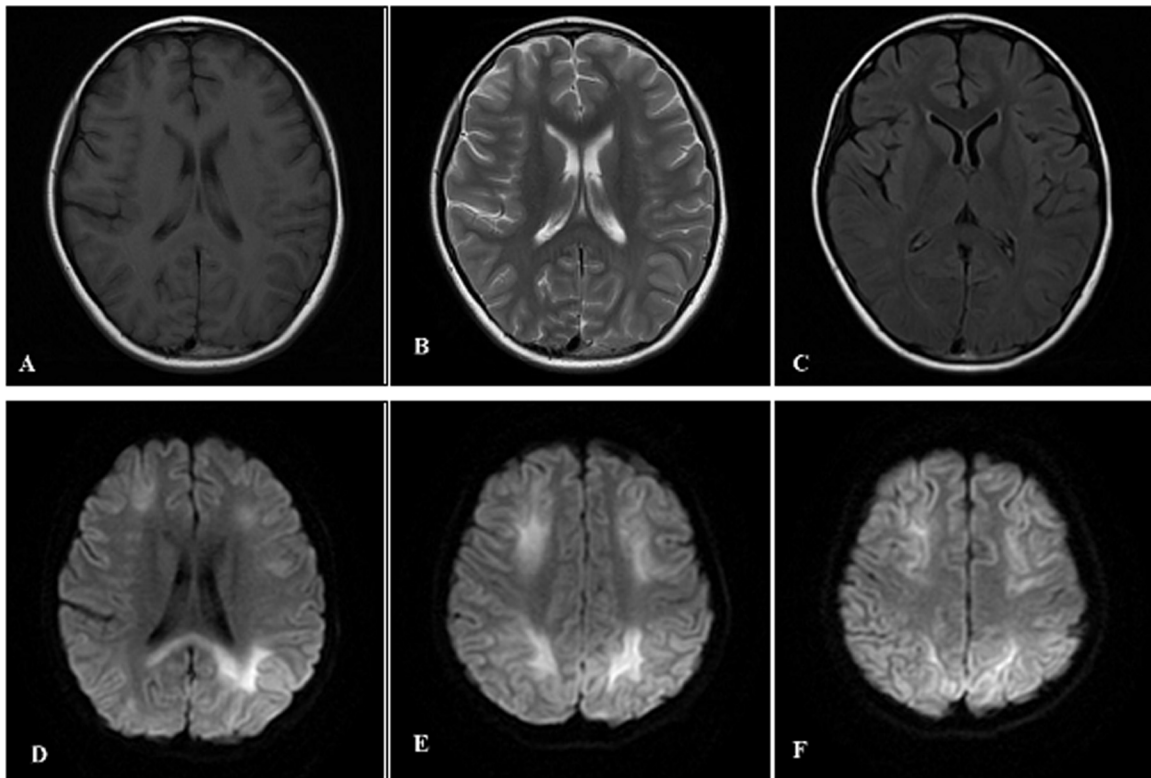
T1W (A), T2W (B), and FLAIR (C) sequences of the initial 3.0-T MRI did not show obvious signal abnormalities, except slight T1W hypointensity (A) and T2W hyperintensity (B) in the splenium. However, widespread DWI signal intensity hyperintensities were shown in different cortical areas, especially bilateral and symmetrical parieto-occipital areas (E and F), and were most marked in the splenium of the corpus callosum (D), with involvement of the white matter of the left posterior horn.
